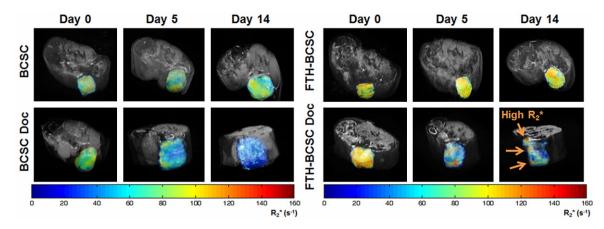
Follow-up volumetric MRI images of BCSC, BCSC treated with docetaxel (BCSC Doc), FTH-BCSC and FTH-BCSC treated with docetaxel (FTH-BCSC Doc). After docetaxel treatment, the mean R2\* values of the BCSC Doc and FTH-BCSC Doc tumors were significantly decreased compared with the BCSC and FTH-BCSC tumors at days 5 and days 14. Moreover MRI images, revealed significantly different signal intensities (R2\* values) between FTH genestransduced BCSCs (FTH-BCSC & FTH-BCSC Doc) and wild type BCSCs (BCSC & BCSC Doc) [69].
